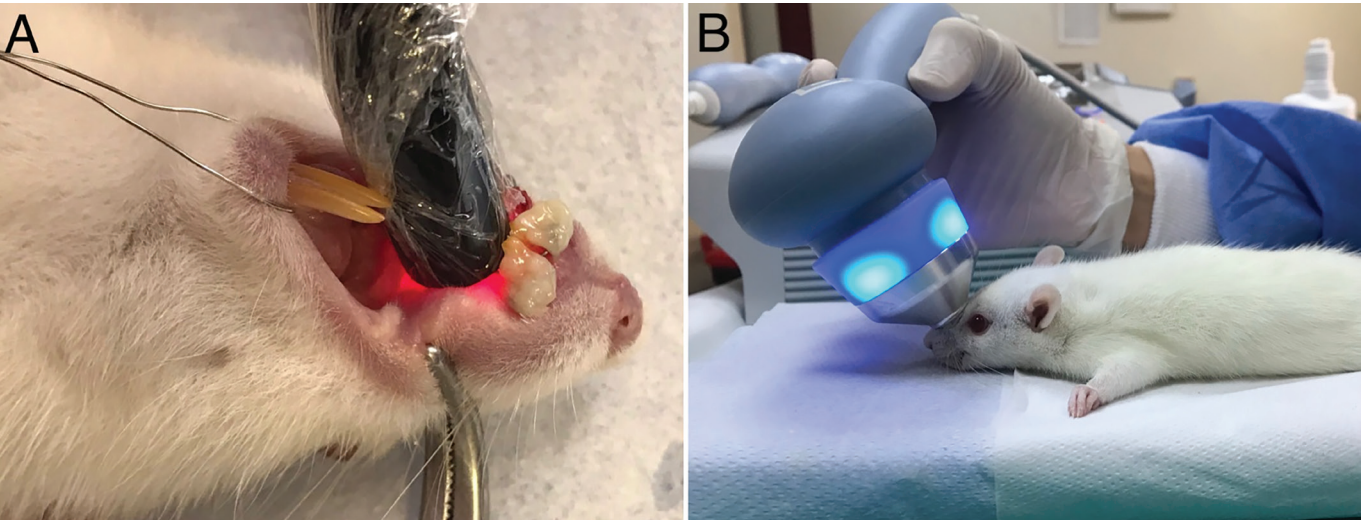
(A) LLLT and (B) LIPUS treatments. LIPUS, low-intensity pulsed ultrasound; LLLT, low-level laser therap.
